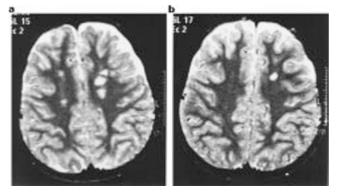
Brain MRI images 4.5 months (a) and 1 year (b) after BMT showing disappearance and decreasing of signal intensities of the lesions.
